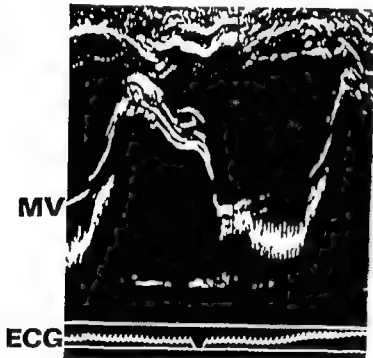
Mitral valve echocardiogram demonstrating larger amplitude, higher frequency (80 Hz) systolic flutter. This record is from the same patient as Fig 1.
